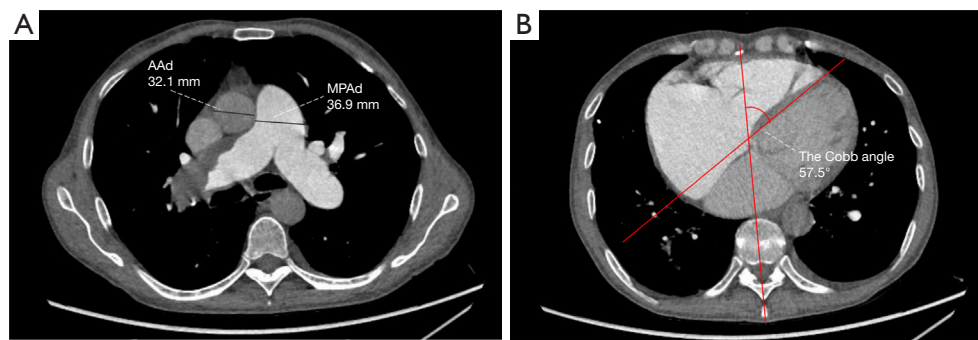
The vascular diameters and Cobb angle measurement from transversal computed tomography pulmonary angiography images. (A) The widest MPAd and the widest AAAd at the same level were measured at standard axial images. (B) The Cobb angle, the angle between the interventricular septum and the line connecting the midpoint of the sternum and the thoracic vertebral spinous process, was measured during diastole in the transversal image. MPAd, diameter of the main pulmonary artery; AAAd, diameter of the ascending aorta.
